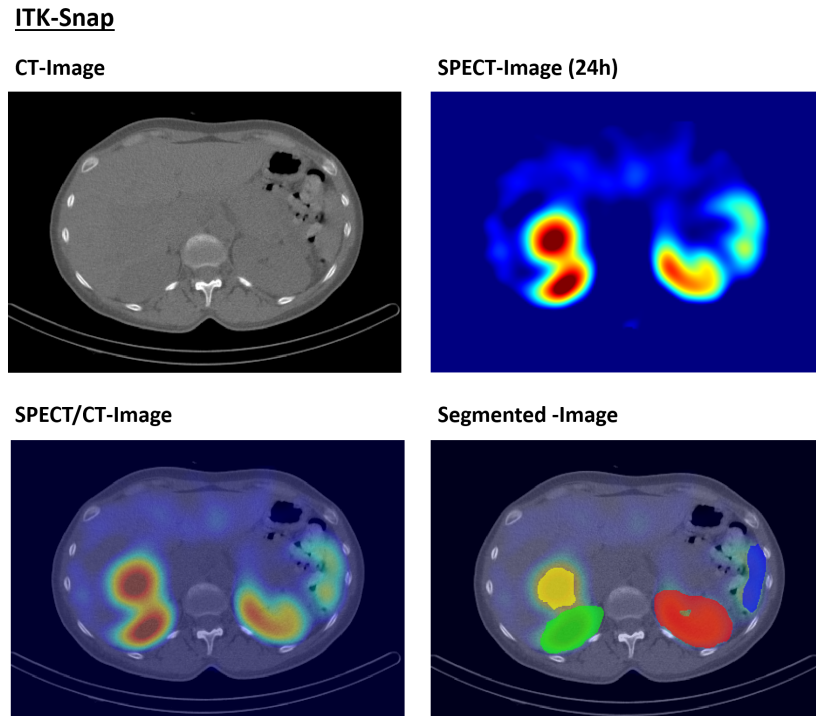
CT-image, SPECT-image and hybrid SPECT/CT-image as shown in ITK-snap. In the right bottom corner the segmentation of the right and left kidney, the spleen and a liver tumor can be seen.
